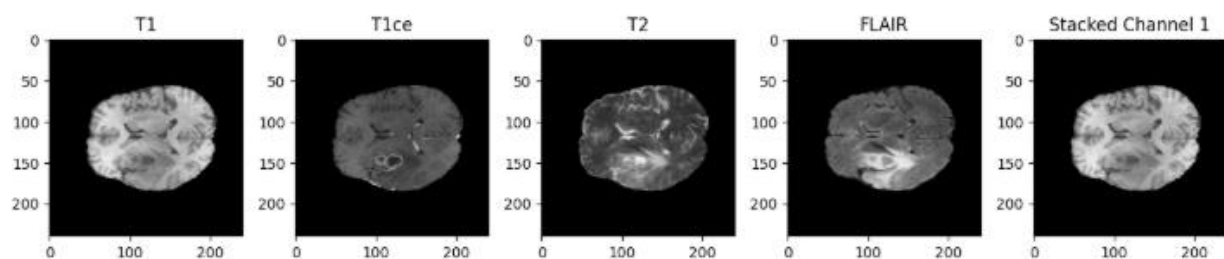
Channel-wise stacking of multimodal MRI slices
